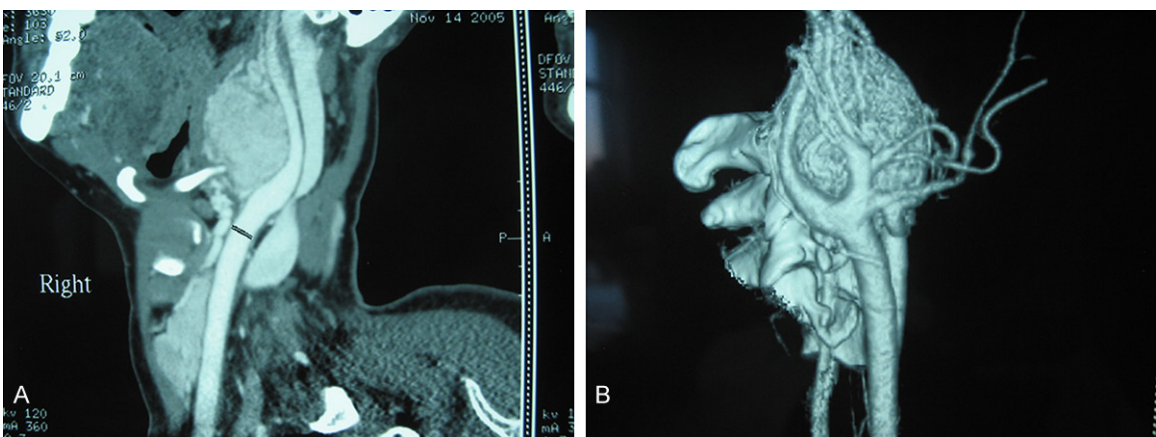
A: CTA showed the carotid body tumor; B: CTA imaging demonstrated the typical separation of external and internal carotid arteries of a carotid body tumor.
